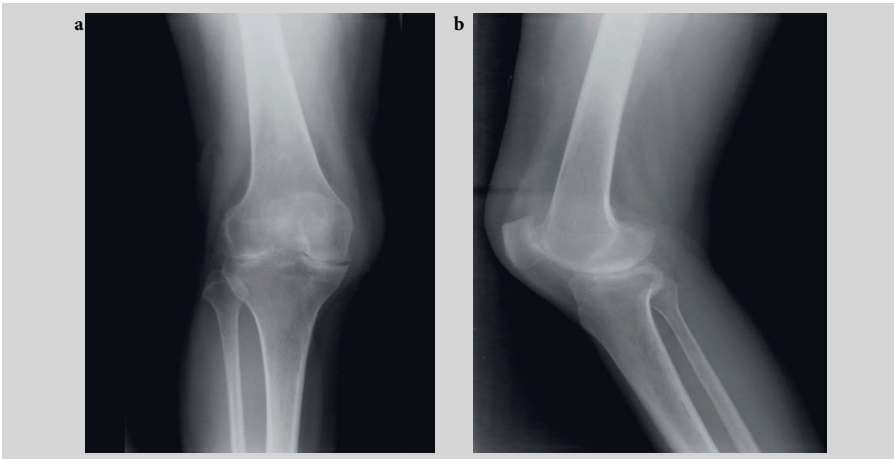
Posteroanterior (a) and lateral (b) radiographs of the knees demonstrate diffuse tricompartamental joint space narrowing with suprapatellar effusion. Marked muscle atrophy is noted in the quadriceps of both legs and the degree of widespread cartilage loss is very striking.
